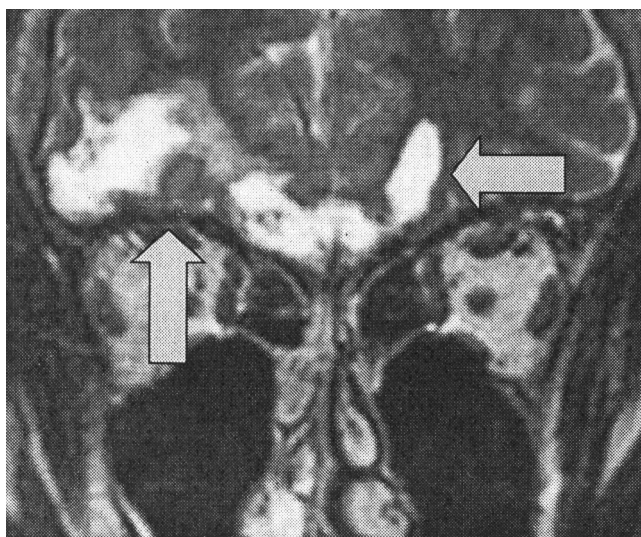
T2-weighted coronal image with decreased olfactory bulb volume and significant damage in the frontal lobe area and in the temporal area (arrows). Note that this section is more posterior than Figures 3, 4, and 5.
